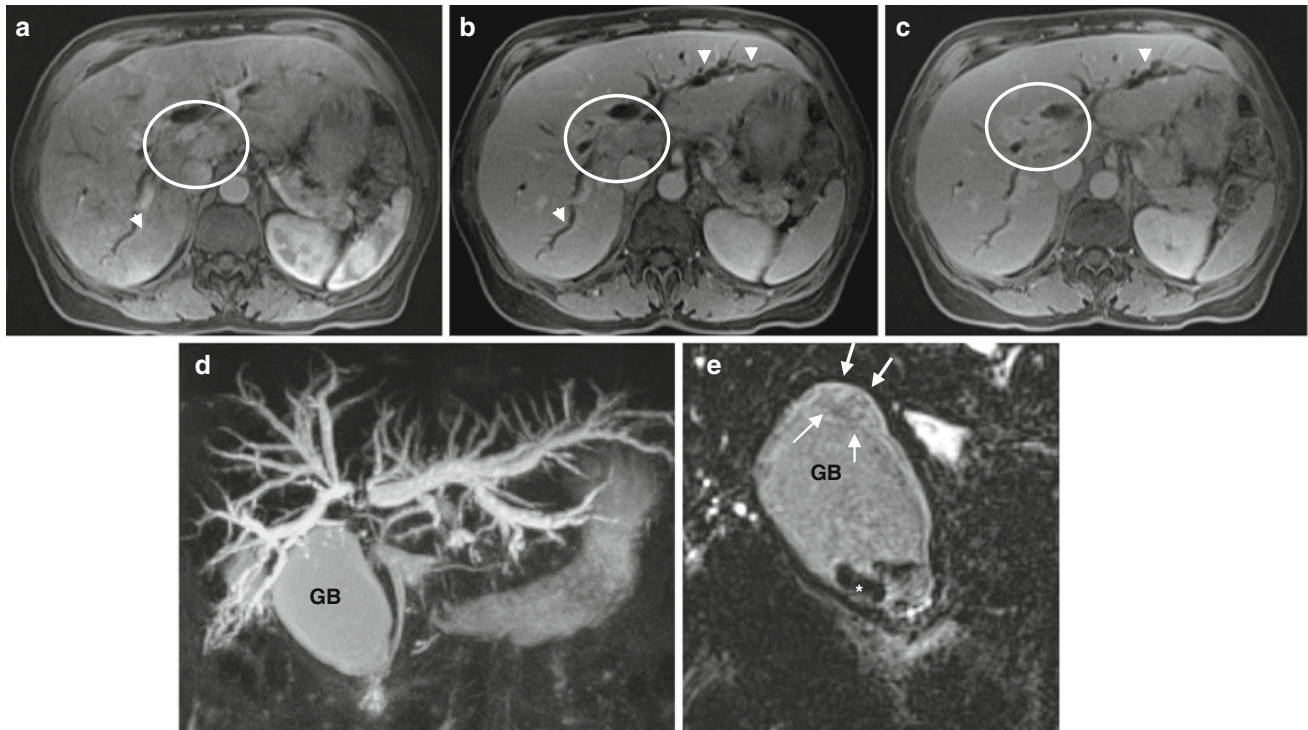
A 69-year-old male with diagnosis of metastatic gallbladder adenocarcinoma. Contrast-enhanced MRI demonstrates (a–c) extensive intrahepatic ductal dilatation (arrowheads) with abrupt truncation at the hilar region related to an infiltrating mass measuring 4.2×2.6 cm (circle). On the delayed image (c), there is enhancement of the mass at
